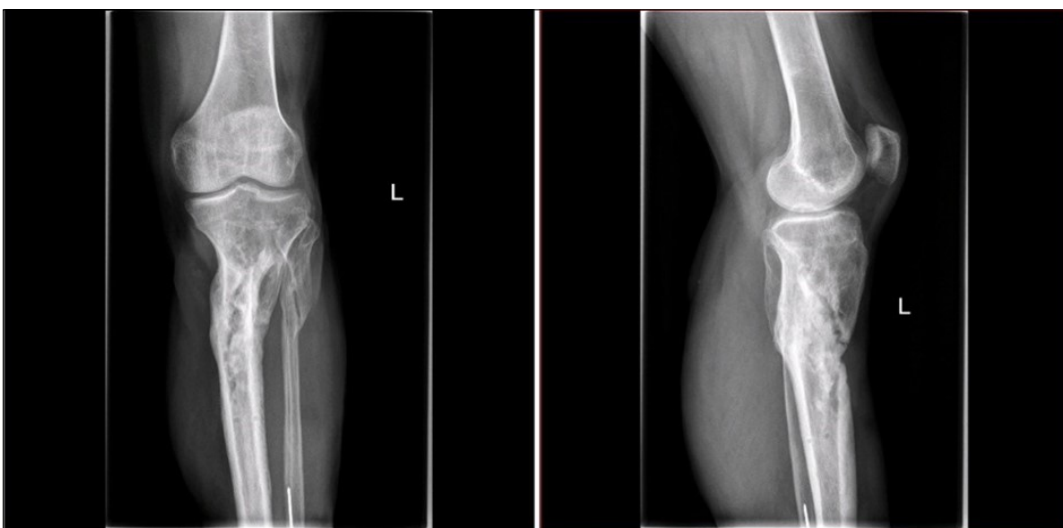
e) 2.2.2017 X-ray
